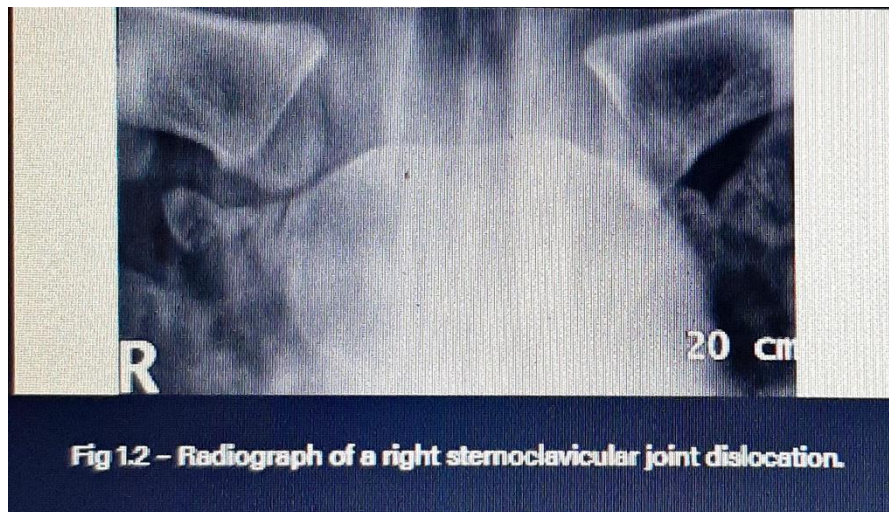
Radiograph of a right sternoclavicular joint dislocation.
